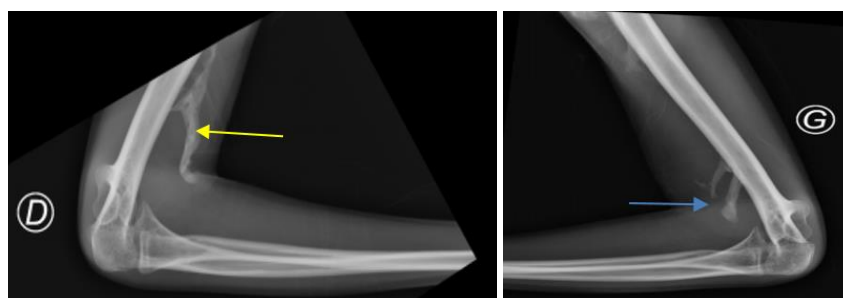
Lateral elbow radiographs
